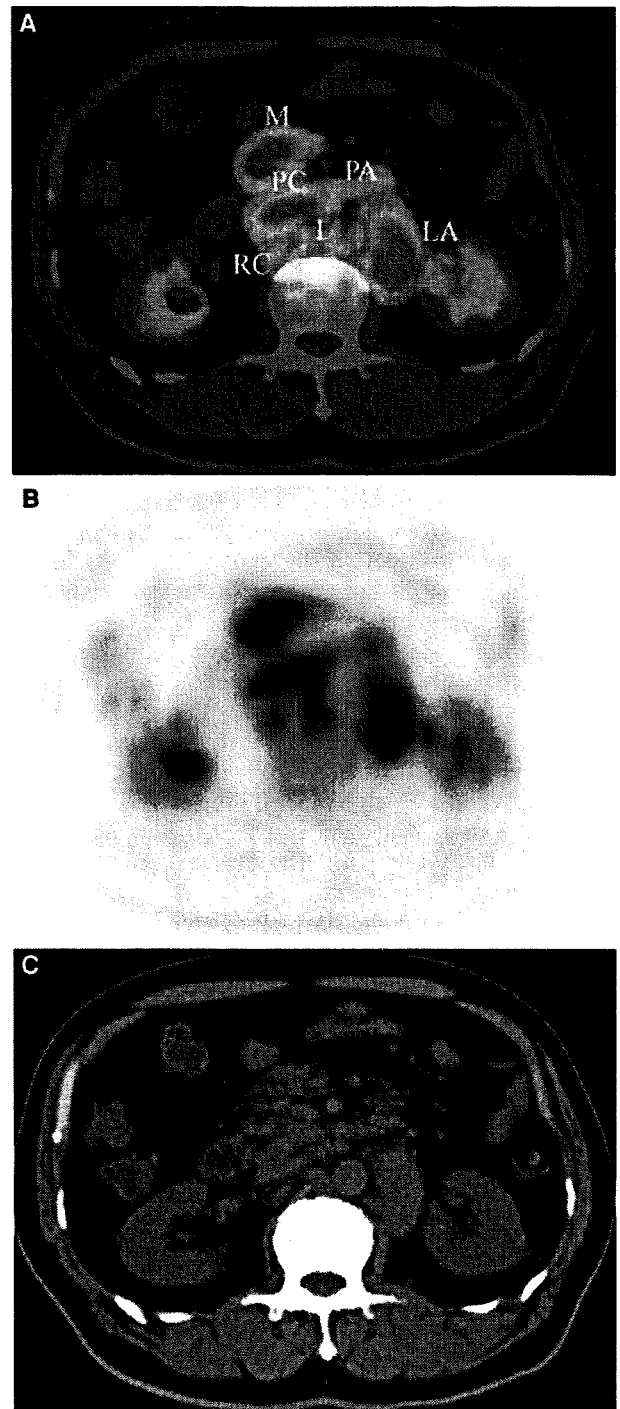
Axial noncontrast PET/CT image (A), PET (B), and CT (C) shows multiple enlarged nodes with increased uptake in patient with follicular lymphoma. LA, lateroaortic lymph node; PA, preaortic lymph node; PC, precaval lymph node; L, intermediate lumbar lymph node; RC, retrocaval lymph node; M, mesenteric lymph node.
